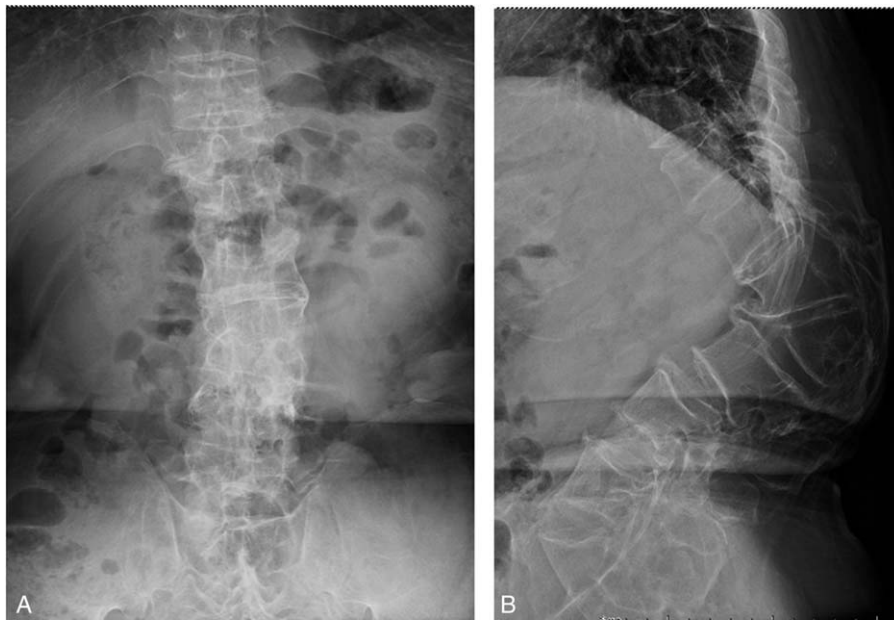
Preoperative anteroposterior and lateral radiographs of the thoracolumbar spine. Preoperative anteroposterior radiographs demonstrate a decreased interpedicular distance. Preoperative lateral radiographs show L2 anterior wedge deformity, fusion of the anterior area from the L1 to L3 vertebrae, and thoracolumbar kyphosis (105° , L1–L3).
